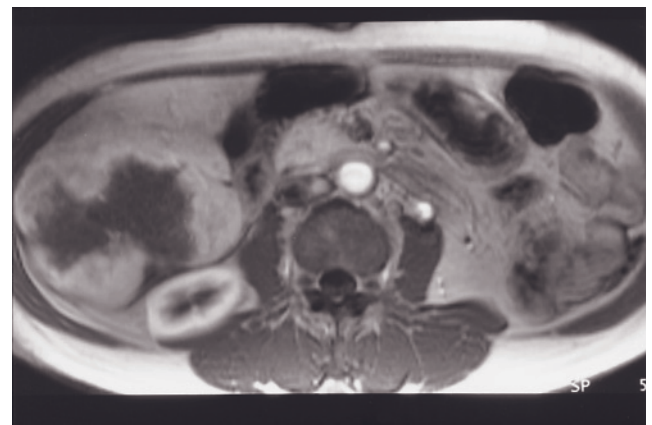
(Continued) Fat-suppressed T2-weighted ETSE (g), SGE (h), and 45-s postgadolinium SGE (i) images in a second patient. Note the presence of ascites.
